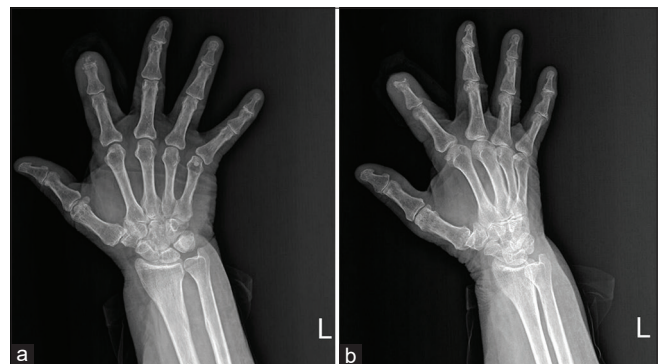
Radiography of the left hand revealed acro-osteolysis of the second left terminal phalanx. (a) Anteroposterior view. (b) Oblique view
